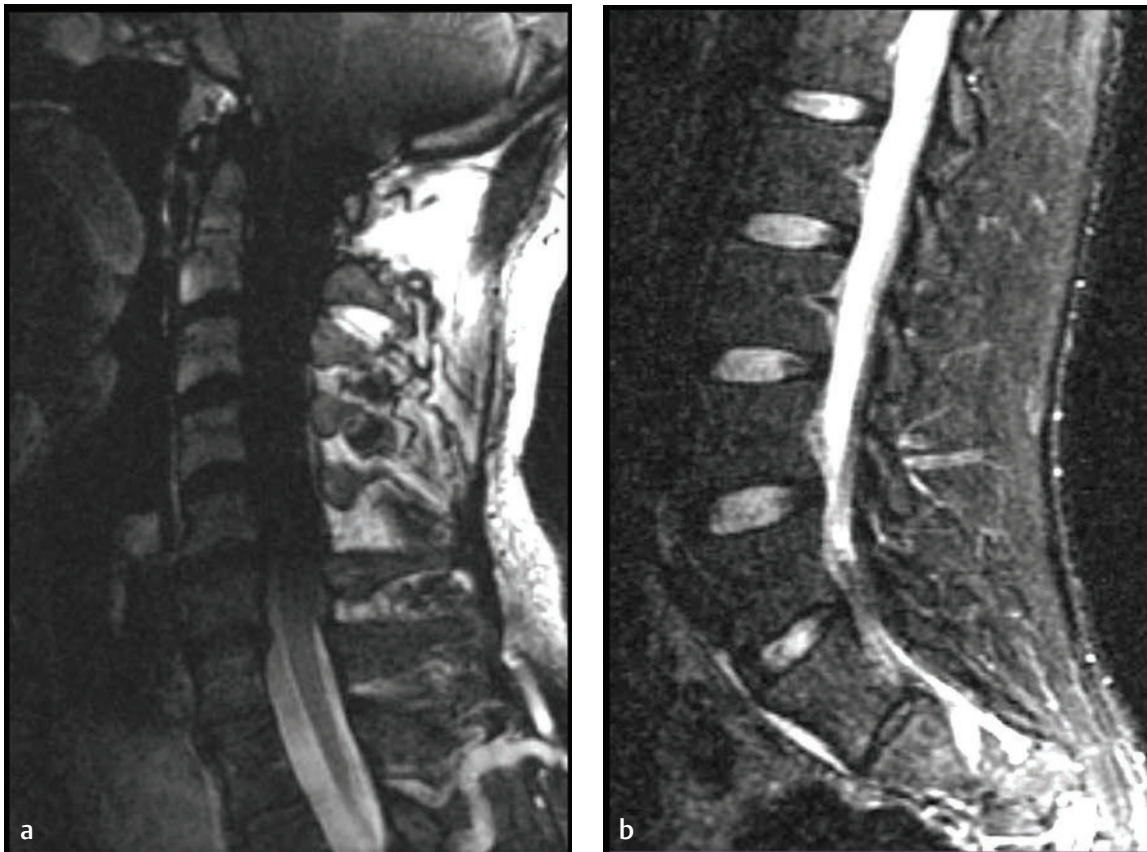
Comparison of fluid-sensitive techniques. (a) A T2-weighted image of the cervical spine with frequency-selective fat suppression shows heterogeneous signal, especially through the cervical spinal canal, due to failure of fat suppression. (b) A sagittal STIR image through the lumbar spine shows homogeneous fat signal because it is an inversion recovery sequence rather than a frequency-selective method of suppression.
